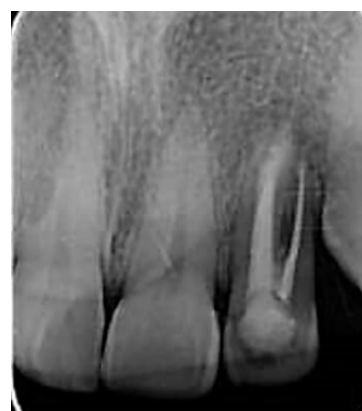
One year follow-up radiograph of #22 showing healing of peirapical lesion
